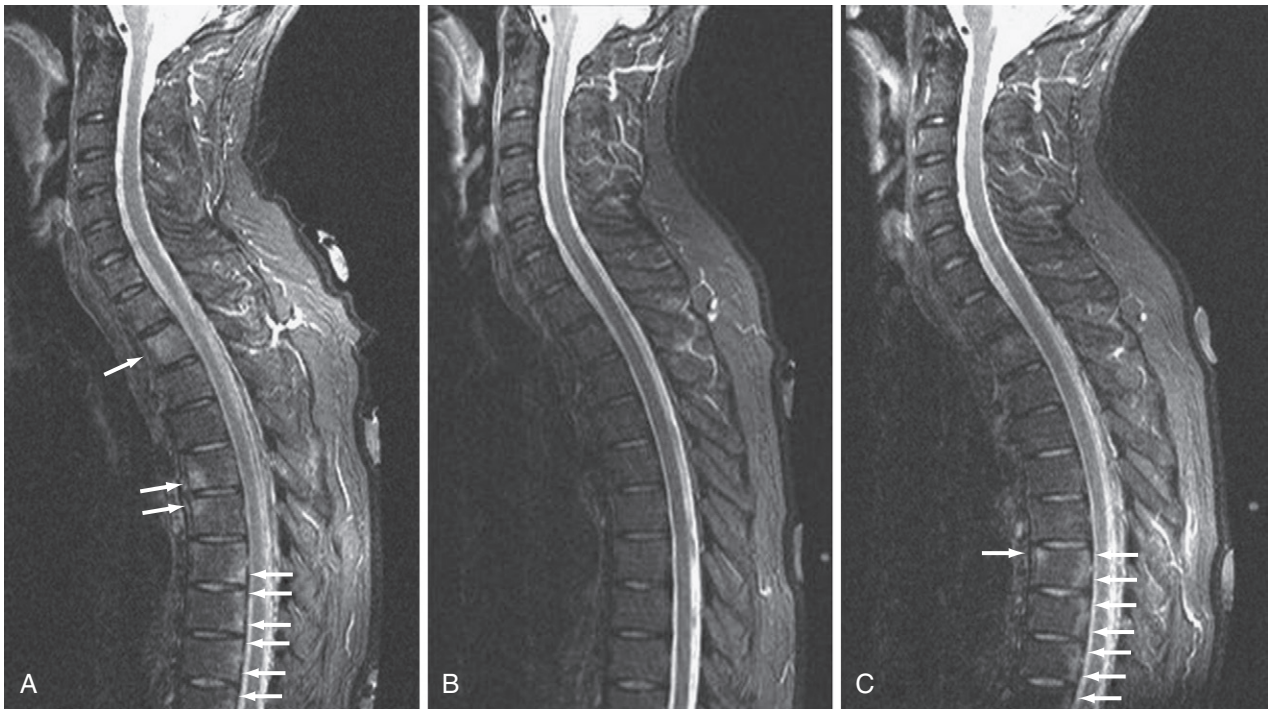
Spine inflammation in ankylosing spondylitis (magnetic resonance imaging [MRI]). A 43-year-old man with HLA-B27–positive ankylosing spondylitis with deteriorating symptoms, including inflammatory back pain, had an MRI scan before starting biologic therapy. Baseline sagittal short tau inversion recovery (STIR) MRI (A) shows diffuse increased signal (edema) in the T2 vertebral body and multiple foci of corner inflammation anteriorly at T5 and T6, and posteriorly at T7, T8, T9, and T10 (arrows). Other images confirmed extensive active inflammation in the spine. The patient responded very well, and after 6 months of therapy, a repeat STIR MRI (B) showed complete resolution of bone marrow inflammation. Subsequently, the patient experienced recurrence of symptoms, and a third MRI (C) was performed (2 months after anti-TNF therapy was stopped). This MRI shows no edema at T5-T6, a conspicuous new lesion anteriorly at T7, and recurrent inflammation posteriorly in the lower thoracic spine (arrows).
